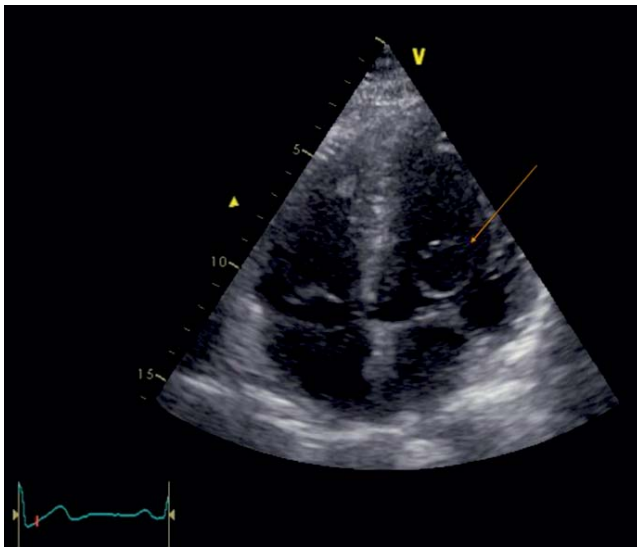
TTE apical 4 chamber, visualization of the blood cyst (arrow) attached to the MV.
